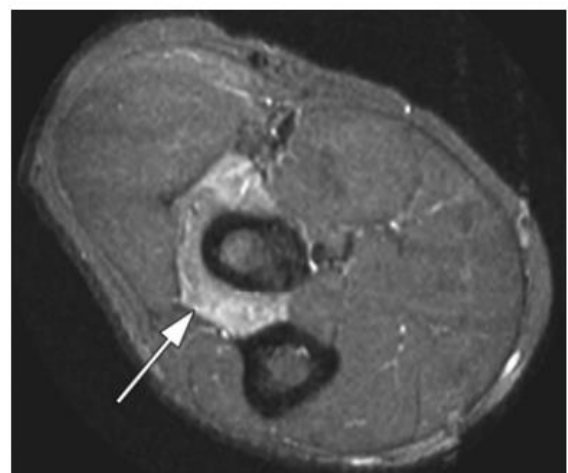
Radial tunnel syndrome. Axial T2-weighted fat-saturated fast SE MR image obtained in a 38-year-old man demonstrates a region of high signal intensity within the supinator muscle, a finding indicative of denervation edema (arrow).
